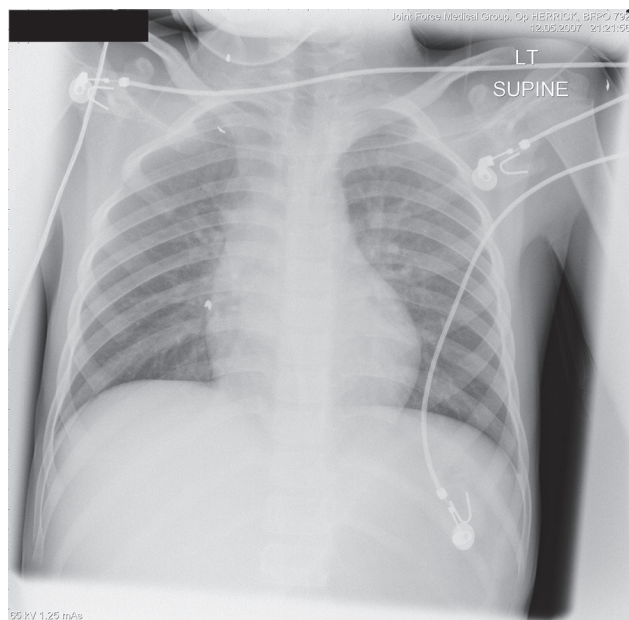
Chest x-ray showing cardiac tamponade.
